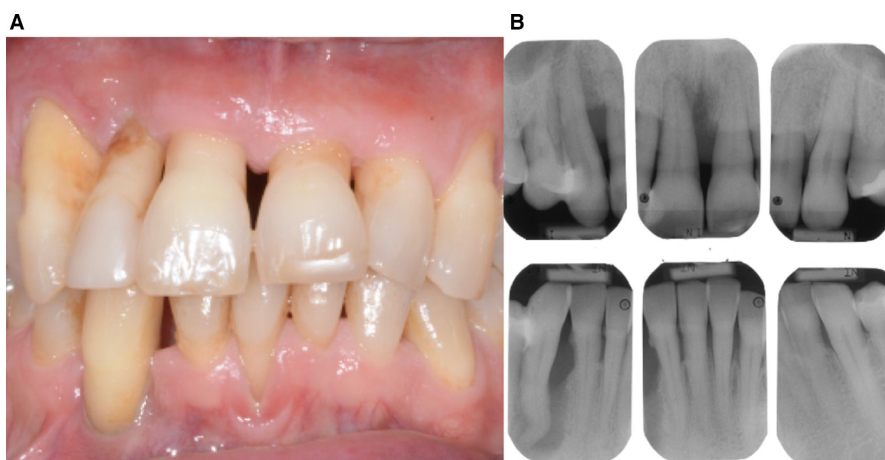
Clinical A and radiographic B evidence of severe periodontitis with increased tooth mobility, tooth migration, gingival recessions, and presence of horizontal and angular alveolar bone destruction.
